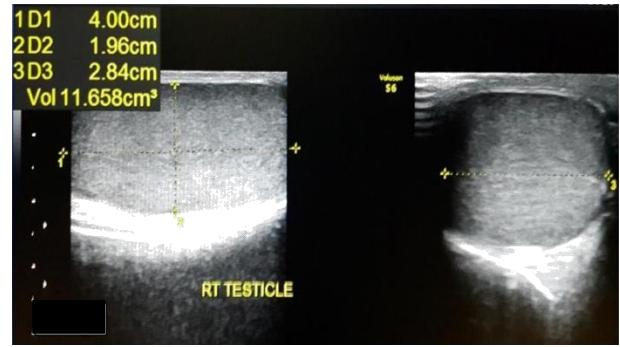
An ultrasonography image shows normal size, shape and echotexture of testicle in an adult.
